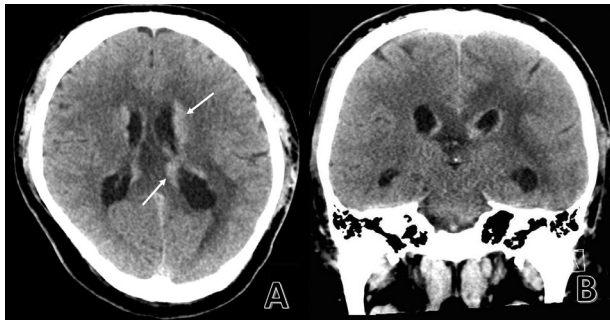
Admission noncontrast CT brain showing diffuse nodular hyperdense lesions lining the lateral ventricles (A, solid arrows) with resultant nonobstructive hydrocephalus (B).
